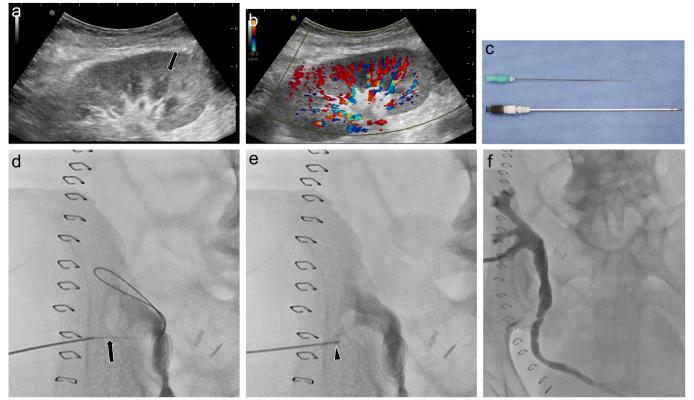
a-f. A 35-year-old woman with a double J stent for ureteral stricture following kidney transplantation presented with elevated serum creatinine level. Grayscale (a) and Color Doppler (b) ultrasonography images show nondilated renal collecting system. Color Doppler image helps identify renal vasculature. The renal pyramid (a, arrow) at the lower pole was punctured. Panel (c) shows a 21 G Chiba needle and a 6 F Neff catheter that were used for puncture. (d) Radiograph after ultrasound-guided puncture of the renal pyramid with a Chiba needle. A small amount of diluted contrast medium was gently injected via the needle (arrowhead) to opacify the renal collecting system. (e) A 0.018-inch guidewire (arrow) was inserted through the Chiba needle into the renal collecting system. (f) Finally, an 8.5 F drainage catheter was successfully inserted.
